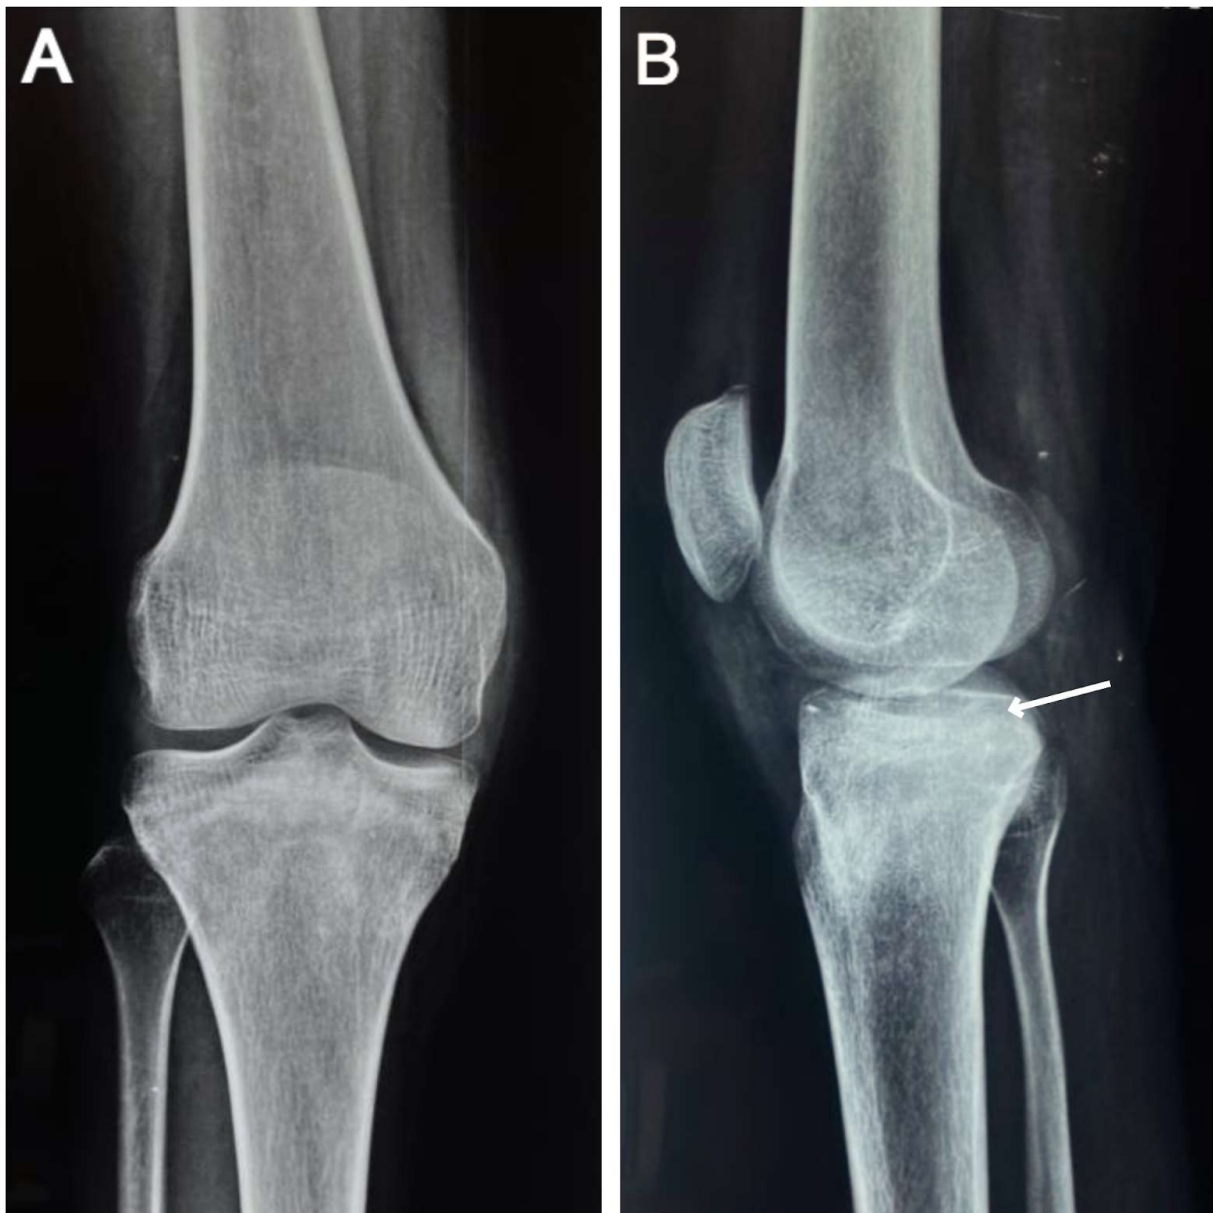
Radiograph showing chondroblastoma. A: Antero-posterior view; B: Lateral view
